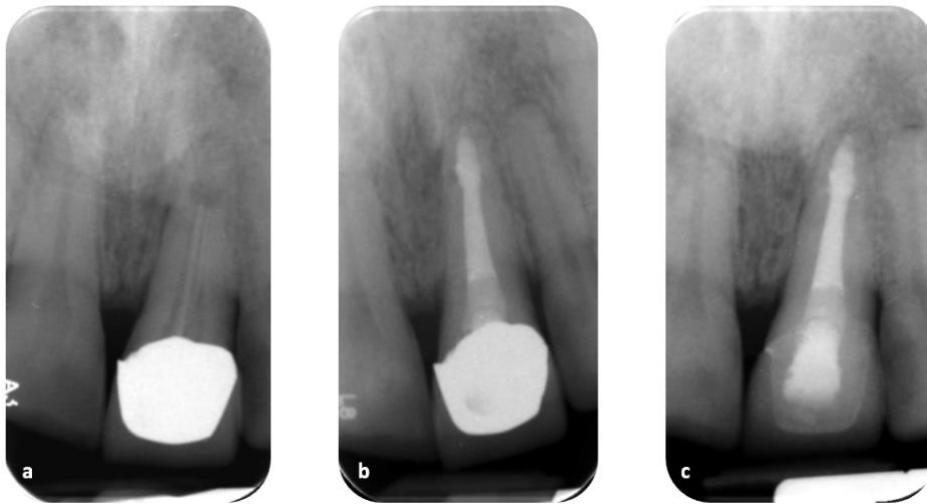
Review of tooth 21 (a) Pre-operative radiograph (b) Postoperative radiograph (c) 1-year review, showing periapical radiolucency is less dense
